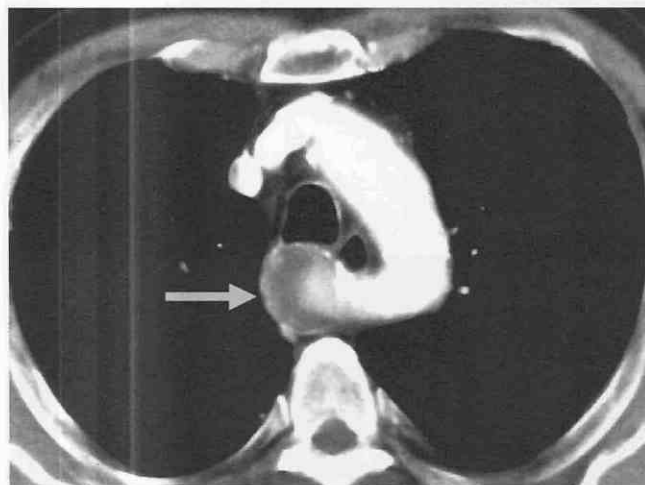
Axial CT scan shows aneurysmal dilatation of the aberrant right subclavian artery (arrow).
